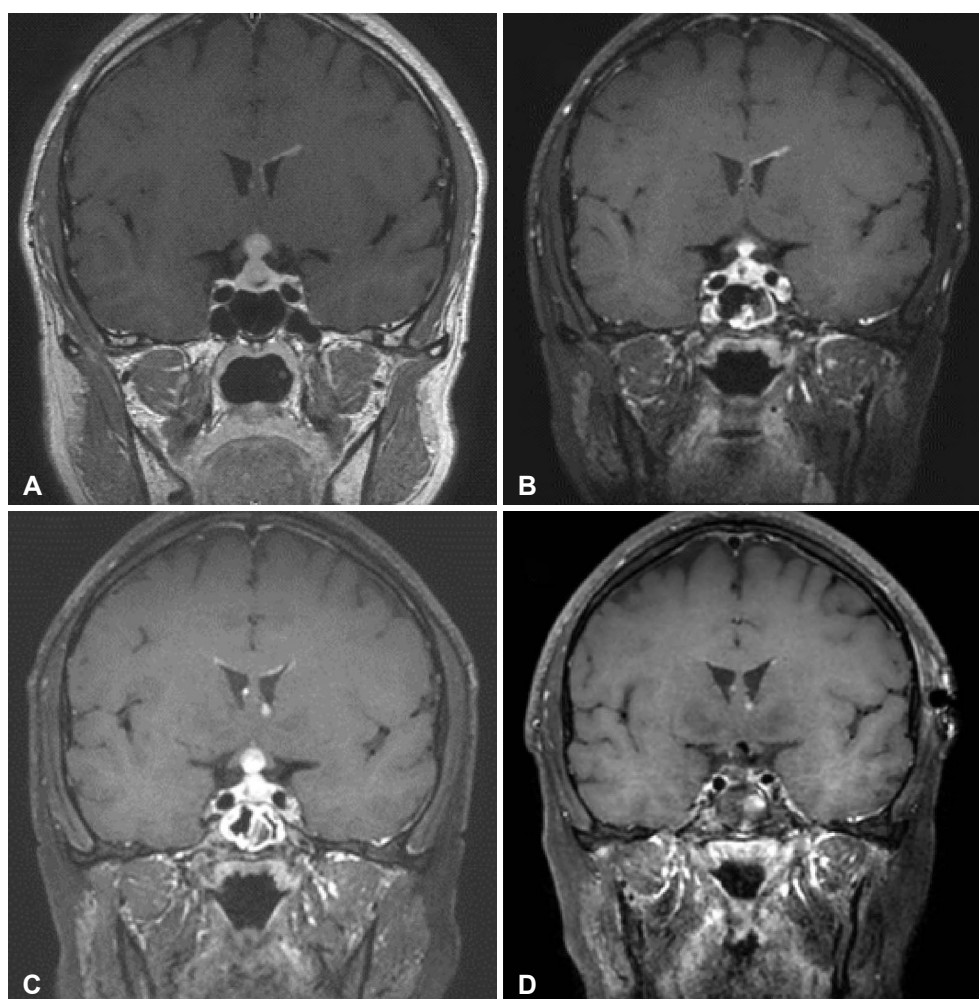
Serial contrast-enhanced T1-weighted magnetic resonance imaging (MRI). A: Initial MRI at presentation demonstrated an enhancing mass lesion in the sellar and suprasellar regions which mainly involves the pituitary stalk and the floor of the third ventricle, along with multiple enhancing seeding lesions along the ventricular wall. B: Follow-up MRI 1 month after the first transsphenoidal biopsy showed a partial reduction in the size of the mass. C: At 3 months post-biopsy, MRI revealed progression of the lesion. D: MRI obtained after the second transsphenoidal surgery showed that the main sellar and suprasellar mass was completely removed.
